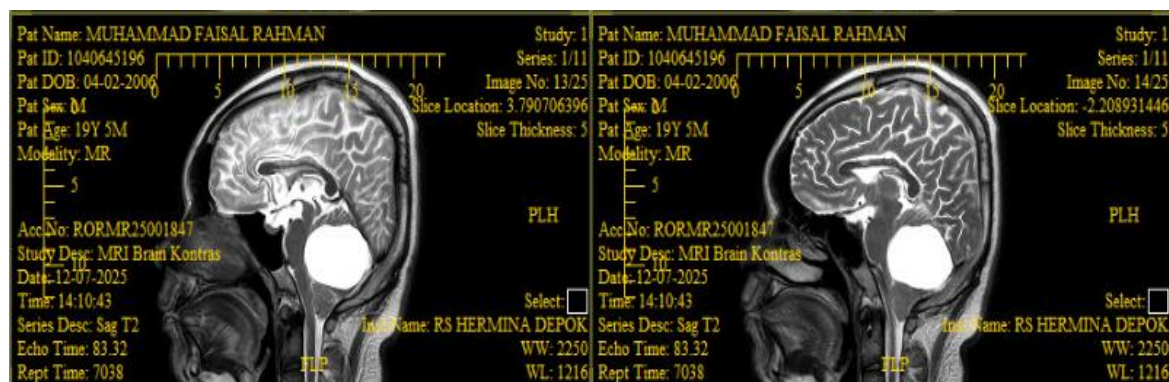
Contrast-Enhanced Brain MRI.
